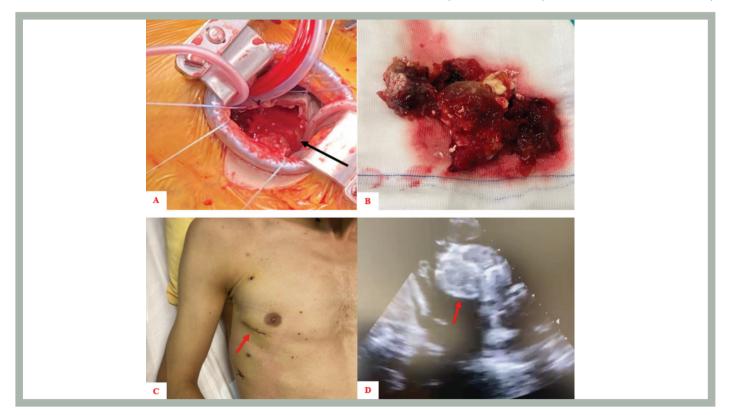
(A) Incision made in the right fourth intercostal space and giant right atrial myxoma seen with black arrow inside. (B) Appearance after surgical excision (could not be removed in one piece due to giant myxoma and small incision). (C) Postoperative view of the incision site. (D) Echocardiographic view of a right atrial myxoma with prolapsed right ventricle
